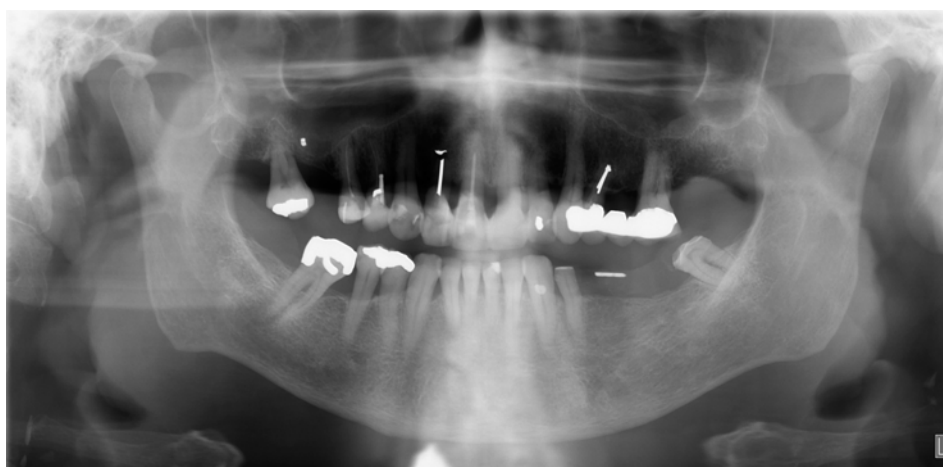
The inferior mandibular cortex on the given panoramic radiograph appears clearly porous (C3 Stage).
